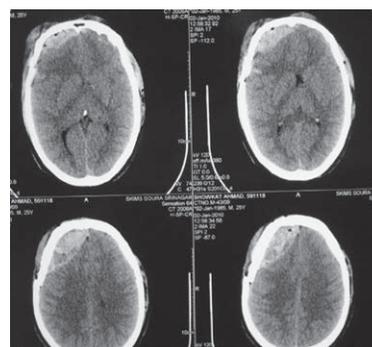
CT head showing EDH in right frontotemporal region with minimal midline shift & there is no sign of EDH on contralateral side
